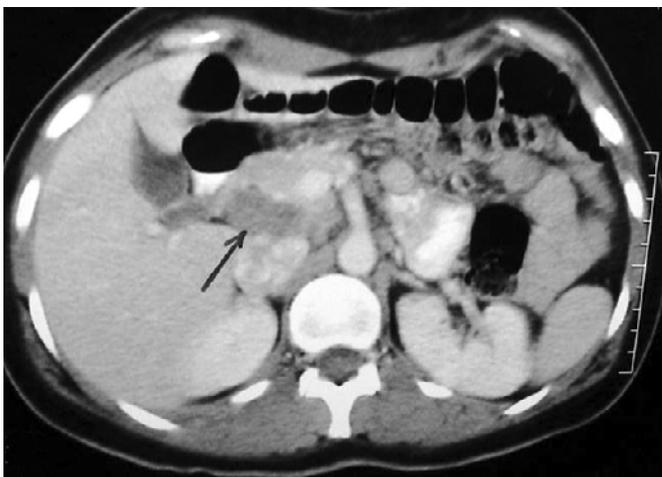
Abdominal CT scan of patient 2 shows peripancreatic lymph node enlargement (arrow).
